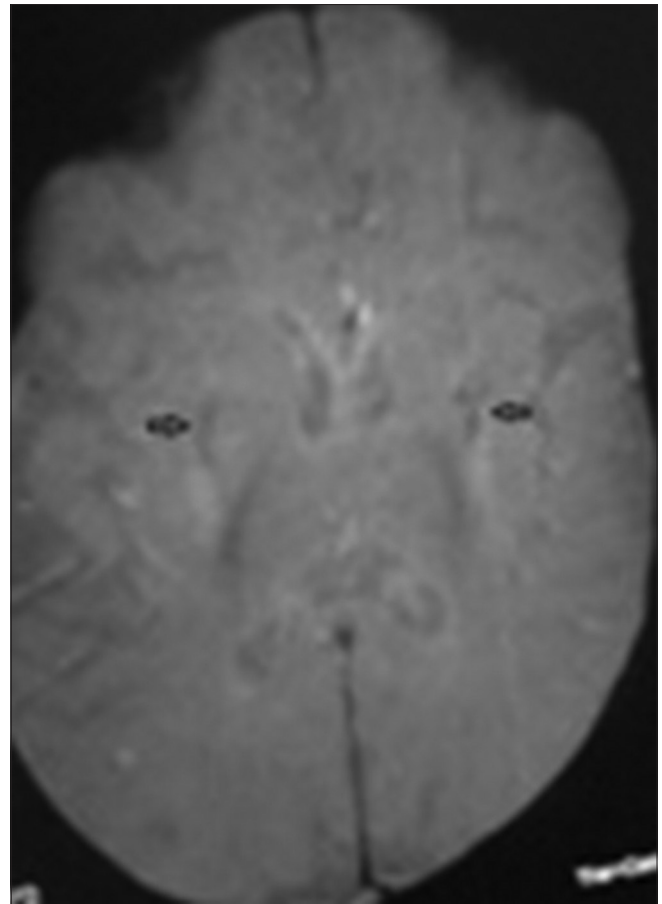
Susceptibility-weighted axial MRI (T2) at the level of basal ganglia shows indistinct loss of signal/blooming (arrow) in the region of lentiform nuclei which is seen as hyperintense on T1W and T2W images
